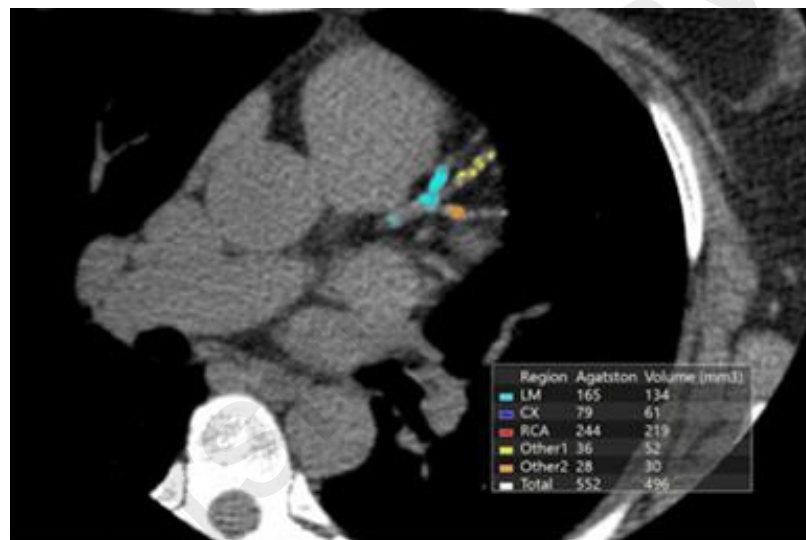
CT Coronary artery image with calcium scoring based on Agatston method
